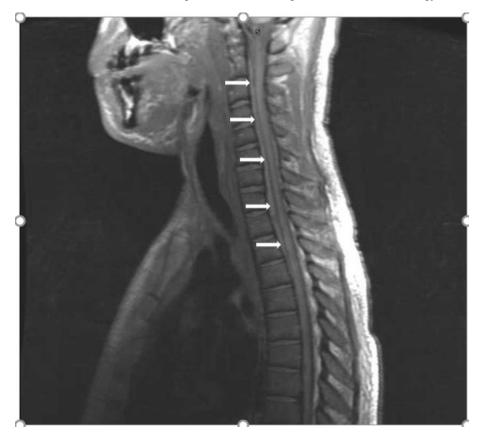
MRI Cervical and Thoracic Spine Sagittal Subtle intermediate T1 signal ventrally in the spinal canal extending from C2 to T4 (Solid white arrows).
